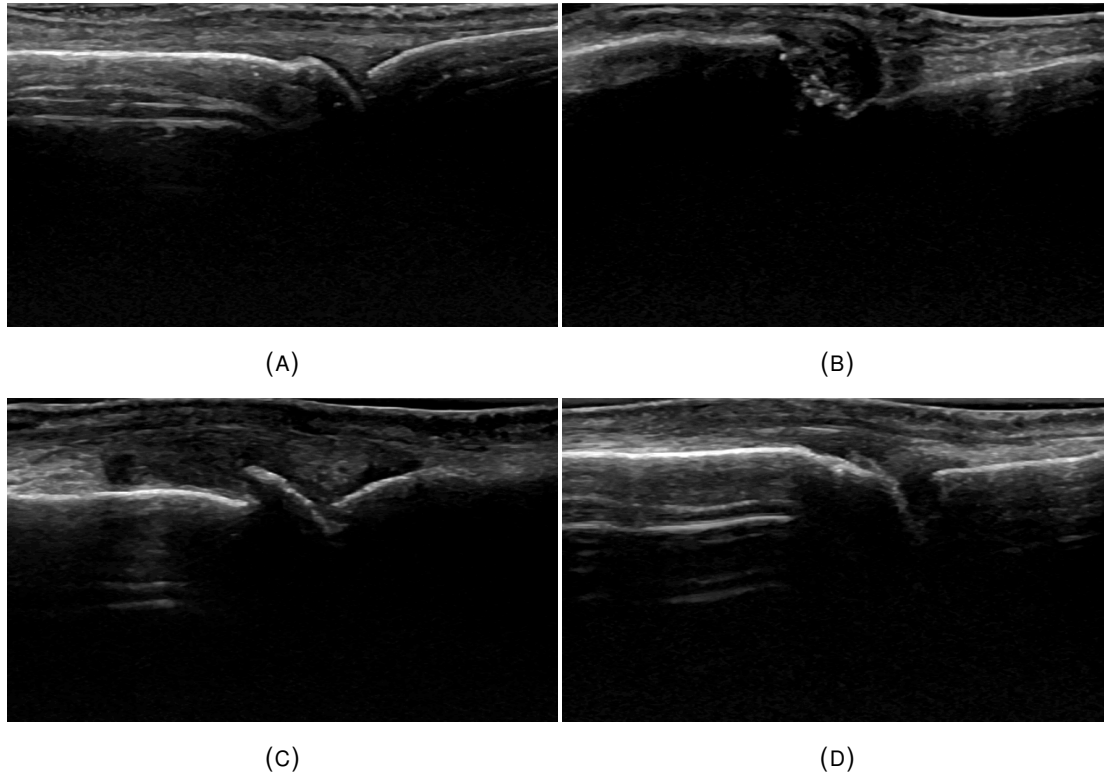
Examples of ultrasound images of the dorsal view of the second metacarpophalangeal joint. A) normal image; B) bone erosion with subluxation; C) osteophyte; D) reverberation artifact.
